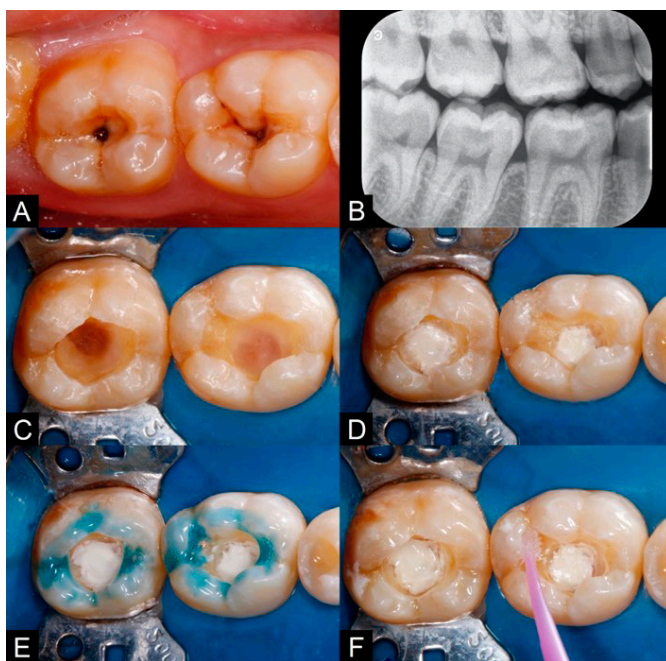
Initial photographs. A. Carious lesions on the occlusal surfaces of teeth 46 and 47. B. Initial Bitewing radiograph. Radiolucent image in dentin compatible with deep carious lesion. C. Removal of caries lesions. D. Application of the calcium silicate-based liner on the dentin close to the pulp chamber. E. Selective enamel etching with 37% phosphoric acid. F. Application of the self-etching adhesive system.
